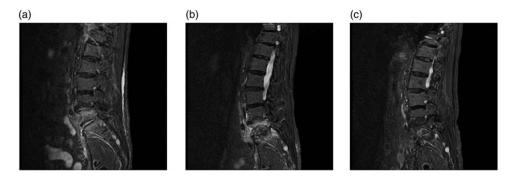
(a) Magnetic resonance imaging (sagittal plane, short-term inversion recovery sequence) on the 8th day shows ventral soft tissue oedema and disc inflammation at the L5–SI levels with bone oedema of the two adjacent vertebral bodies. (b) Control magnetic resonance imaging after I month shows L5 and SI endplate impression and progression of inflammation. (c) Magnetic resonance imaging I year later shows resolution of the inflammation. The paravertebral soft tissues are without signs of inflammation. The vertebral body L5 is structurally changed with focal impression of the inferior terminal endplate. There are no signs of fluid collection or phlegmonous soft tissue.
